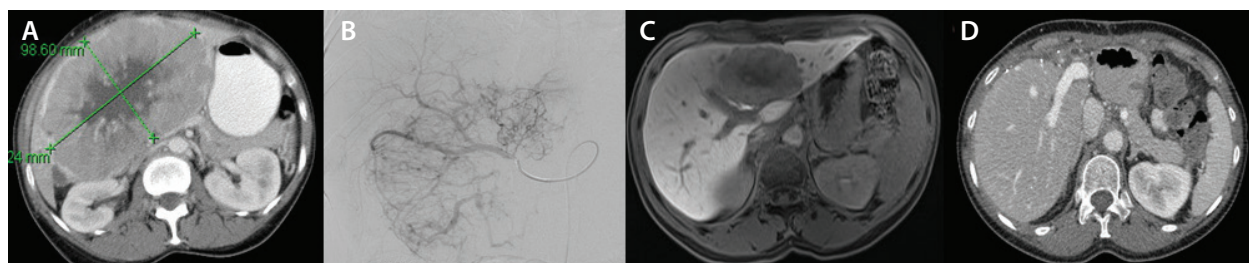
Hepatic resection following tumor downstaging with TACE. Contrast-enhanced CT demonstrating one (of two) large, left liver lobe hepatomas (A). Angiogram obtained during the first TACE procedure out of five total procedures (B), with final follow-up Eovist MRI (Bayer HealthCare; 20-minute delay) demonstrating a marked decrease in tumor sizes (C). Portal venous CT following curative extended left hepatectomy with right liver remnant (D).
